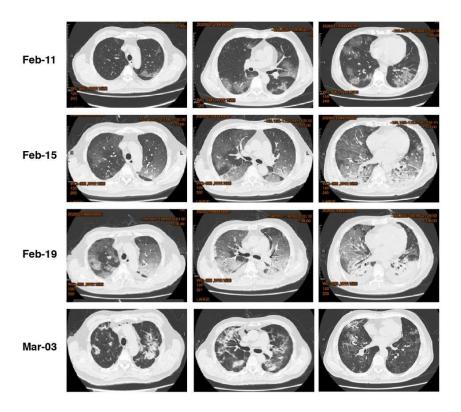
The computed tomography (CT) images for our case patient, which were performed on February 11 (illness day 4), February 15 (illness day 8), February 19 (illness day 12) and March 9 (illness day 31), respectively. On February 15, 2020, illness day 8, note the new foci of bilateral ground-glass opacities and the irregular patchy consolidation along the bronchovascular bundles, and also the appearance of a small amount of pleural effusion. On February 19, 2020, illness day 12, CT images show further enlarged and increased density of ground-glass opacities, consolidation, and pleural effusions. On March 9, 2020, illness day 31, the chest CT images demonstrate the extent and intensity of lesions are significantly reduced.
